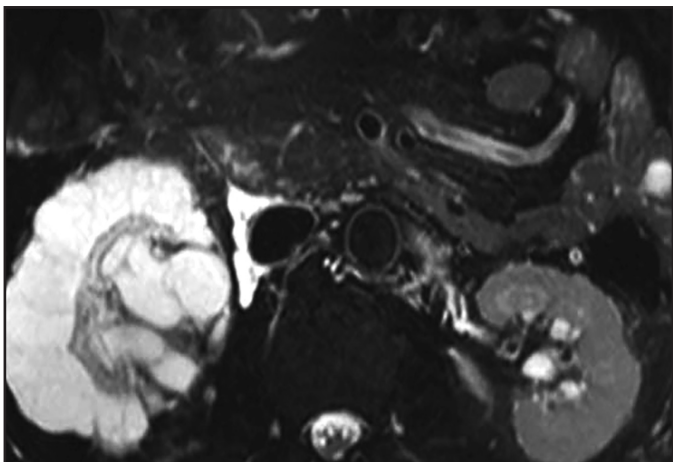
Renal lymphangioma in a 54-year-old man. Axial T2-weighted MR image shows cystic masses in the right perinephric and renal sinus region; additionally, cystic lesions are also identified in the retroperitoneum in pericaval region. This MRI appearance is typical for renal lymphangioma.
